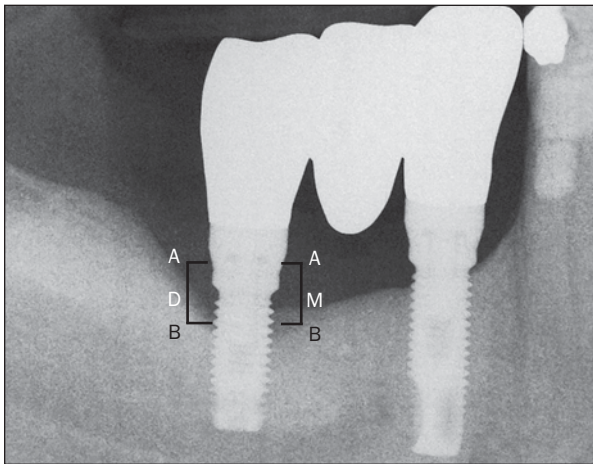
Measurement of radiographic bone loss. A = implant shoulder; B = the most coronal aspect of the alveolar crest; D = amount of bone loss distal to the implant; M = amount of bone loss mesial to the implant.
